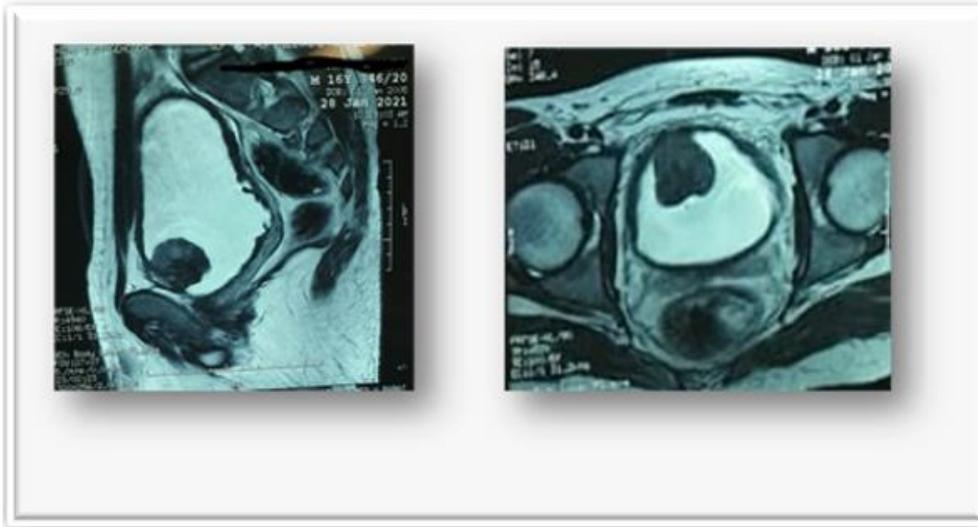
Different sequences of the initial pelvic MRI showing a process invading the left antero-inferior pre-vesical fat in front, and is responsible for bilateral uterus-hydro-nephrosis behind
